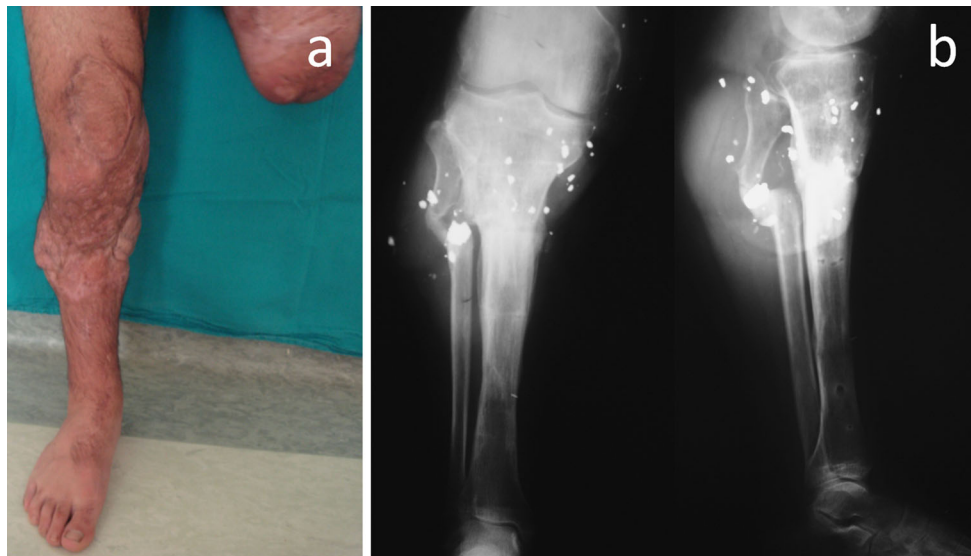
Final clinical appearance (a) and the radiographs (b) of the patient in Fig. 4
